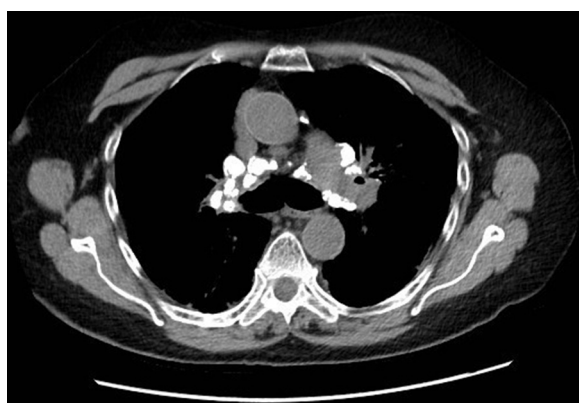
Axial CT scan showing dense lymph node calcifications in bilateral, symmetric hilar and multiple mediastinal compartments in a patient with sarcoidosis.
